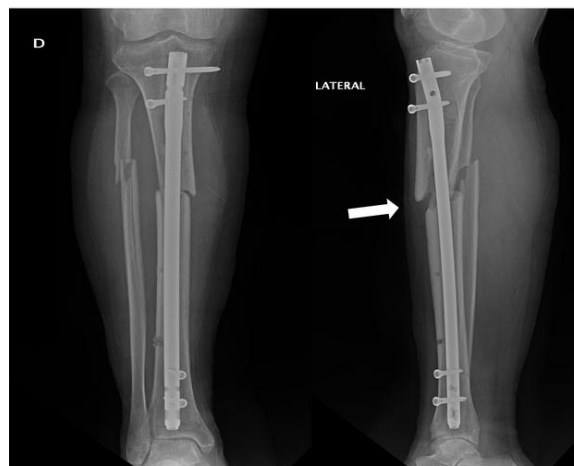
X-ray at 4 Weeks. Swelling Tissue (white arrows)
